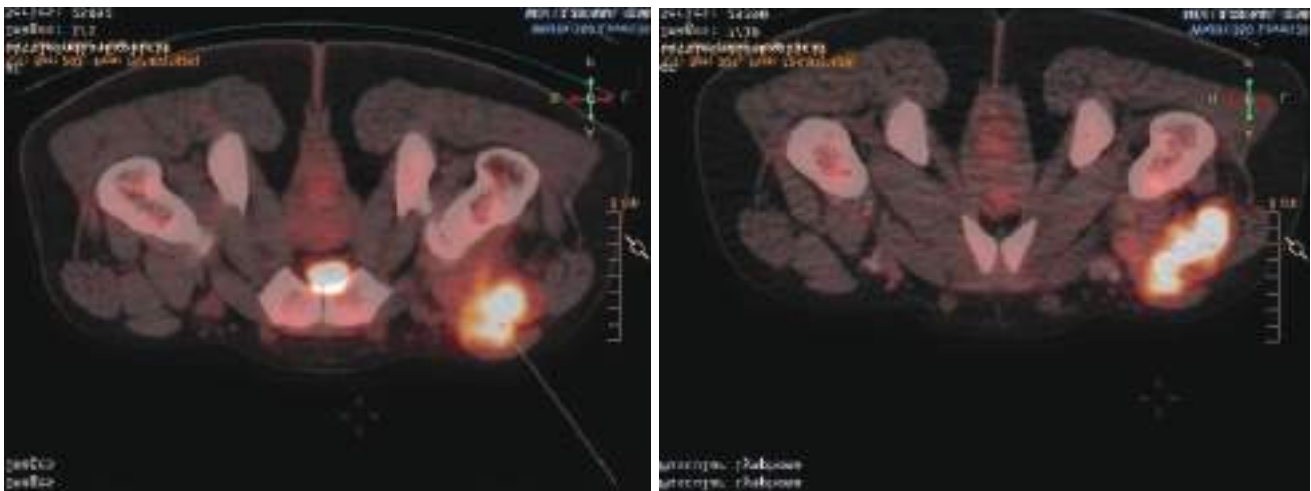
Transaxial fusion PET-CT images show persistent hypermetabolic muscular lesions
